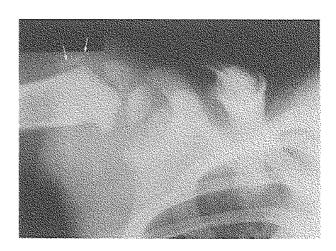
Roentgenogram 2 months after injury: a healed clavicular fracture and a periosteal reaction at the proximal metaphysis of the humerus (arrows.)
